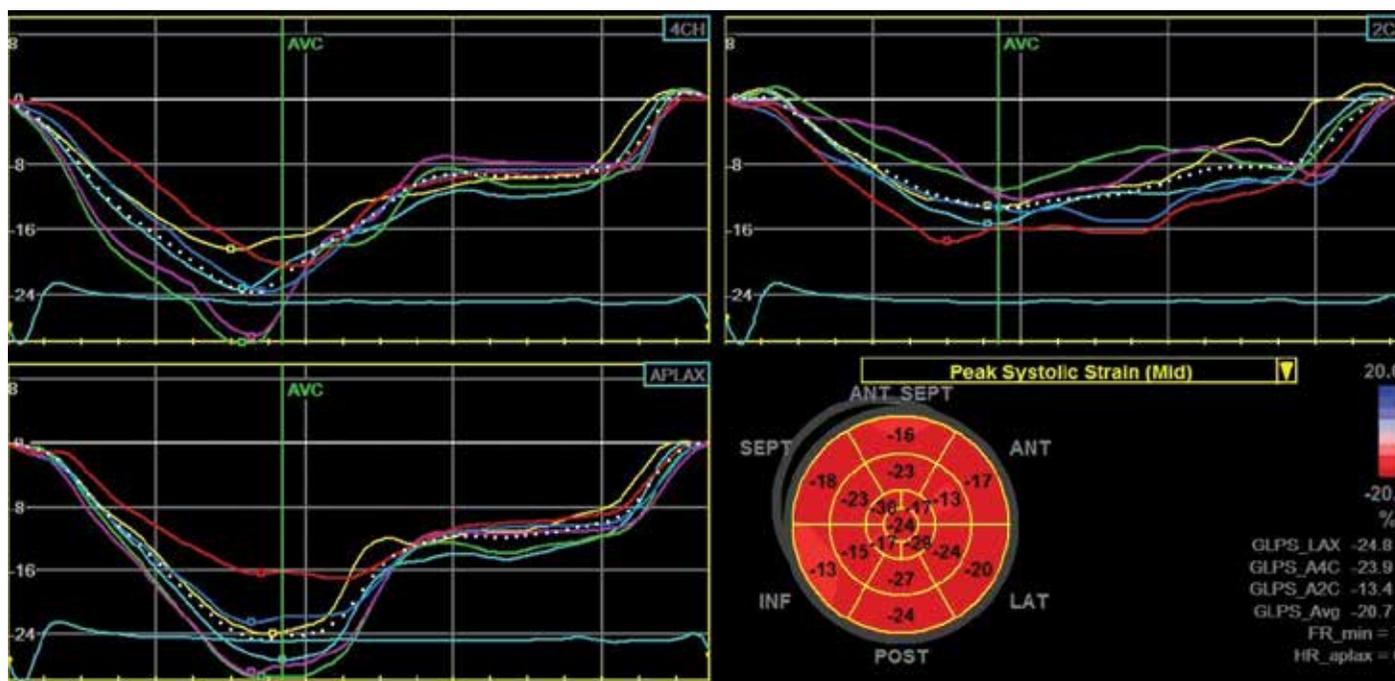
Assessment of LV function using Speckle-tracking echocardiography and measurement of GLS and bulls-eye image of left ventricle
